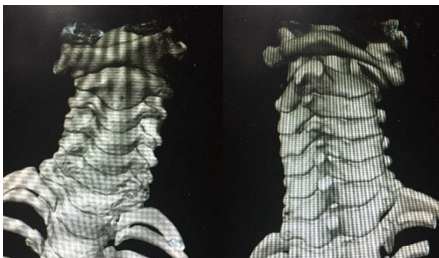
3D CT scan shows atlantoaxial rotatory subluxation
